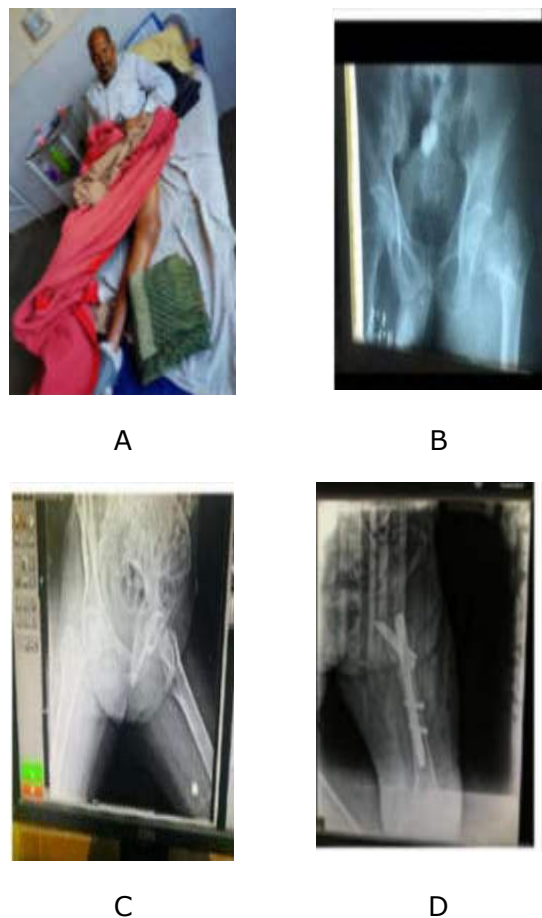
Pre op and post op x-ray of TFN patient
